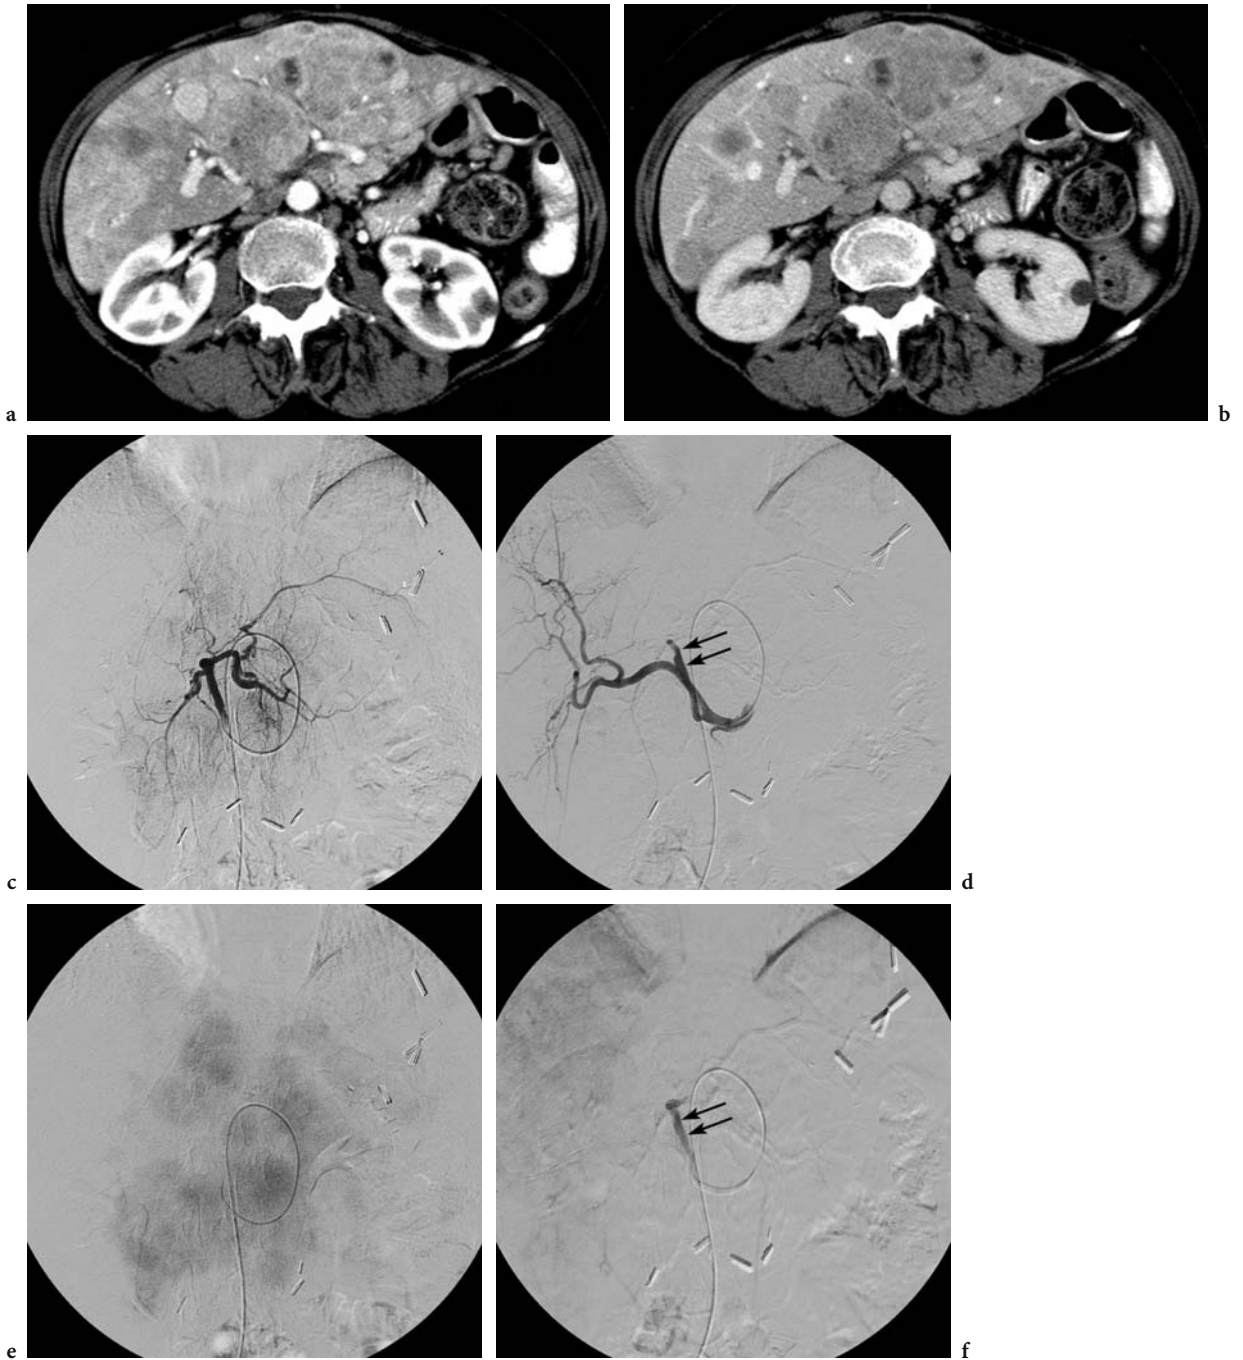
Sixty-four-year-old female with rapidly progressing carcinoid liver metastases. The gastroduodenal artery was surgically ligated at the time of resection of the primary tumor at the gastroduodenal junction 2 years before. Arterial-phase (a) and venous-phase (b) CT images of liver show greater metastatic burden in the left lobe. Selective early (c,d) and delayed (e,f) arteriographic images of left hepatic artery (LHA), before (c,e) and after (d,f) embolization using 5 vials of 100–300 μm tris-acryl gelatin microspheres via a 4 French Cobra II hydrophilic catheter. Arrows denote stagnant contrast column in proximal aspect of embolized LHA. Most of the injected contrast is seen refluxing into the right hepatic artery in (d). Celiac arteriographic images before (g) and after (h) LHA embolization
